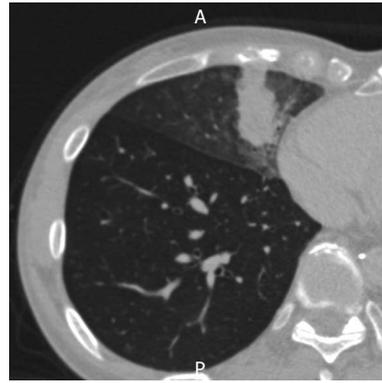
Chest computed tomography showing nodular shadow measuring 26 mm × 16 mm in size with frosted-glass-like shadow in right lung S5.
